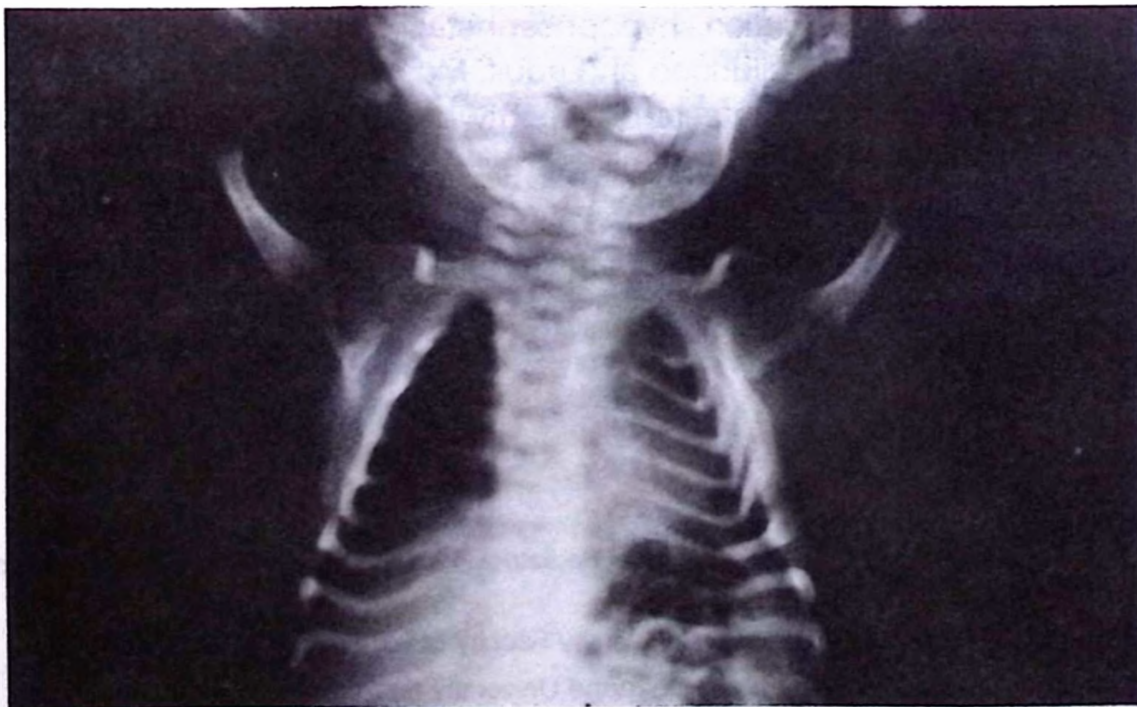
Posterior-anterior chest x-ray showing generalized osteopenia, slight modeling defects in humerus and radius with deformed, thin ribs.
